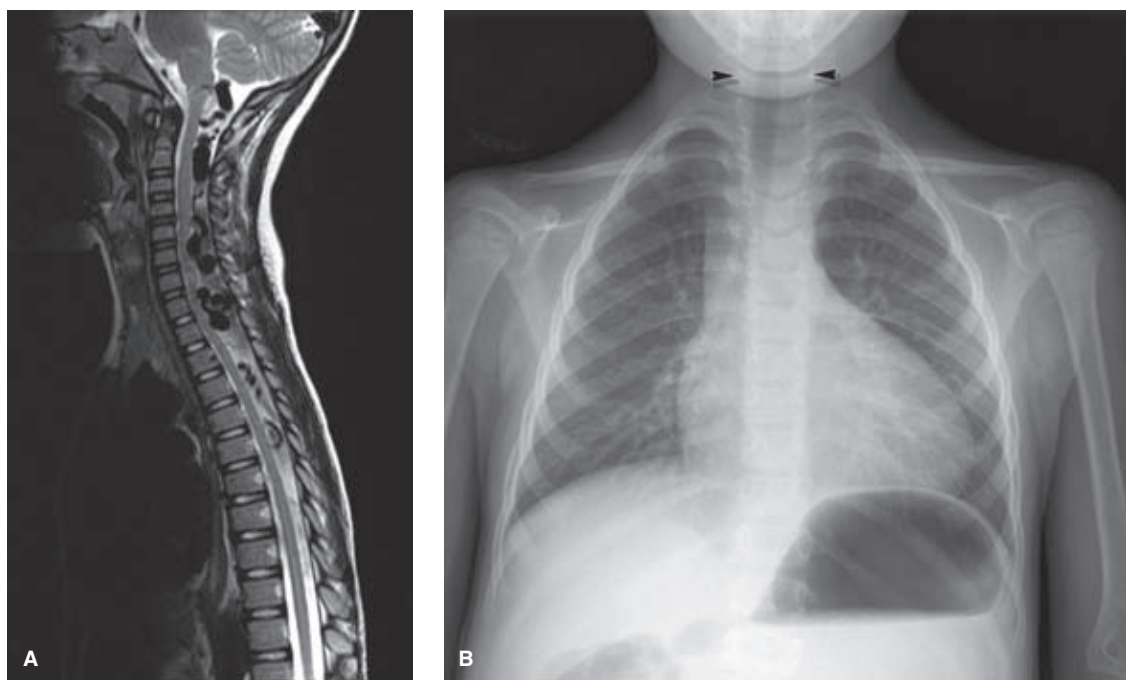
(A–B) Syndromic spinal AVM in a small child. This presumably congenital AVM of the cervical spine was characterized by a number of high-flow fistulas that had resulted in massive distention of the veins of the spinal cord draining upward via the foramen magnum (A). In fact the distended appearance of the basal vein of Rosenthal and mesencephalic veins gave the appearance at first glance that this might be a vein of Galen type of malformation in the tectal region, until one realized the fact that these veins were emerging out of the spinal canal into the cranial vault, instead of vice versa. The chest x-ray in this child (B), who had an audible bruit over his neck and suboccipital area, shows the widened interpedicular distance (*arrowheads*) wrought by such lesions when they occur early in development.
